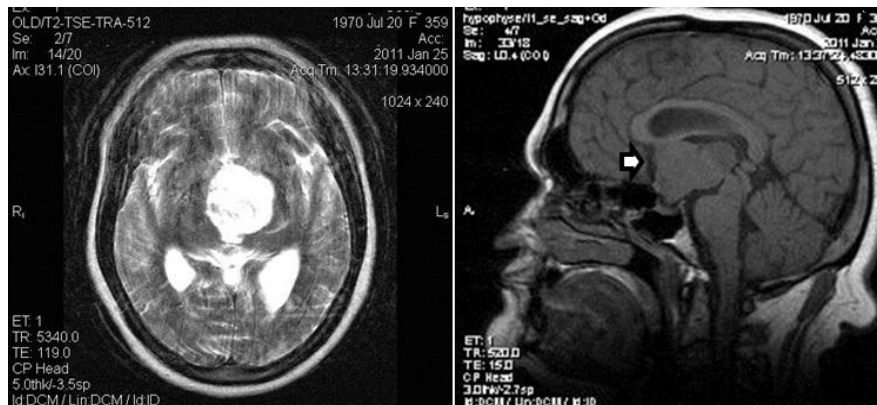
MRI image (axial and sagittal) of intra- and suprasellar craniopharyngioma
